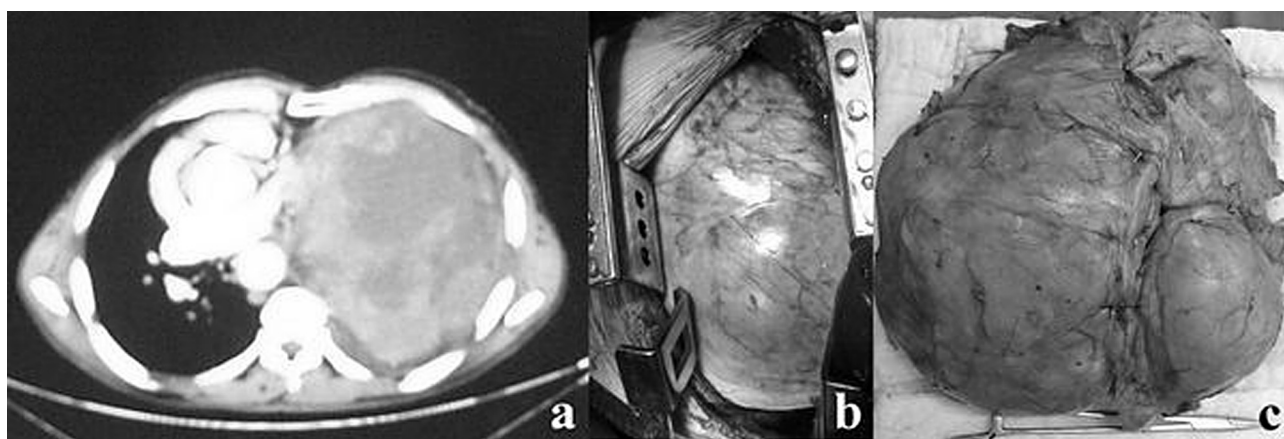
Preoperative CT scan. 1b. Intraoperative view of the giant leiomyoma. 1c. Resected mediastinal leiomyoma.
